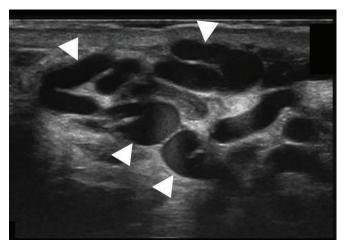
Ultrasound scan showing numerous distended veins (arrowheads) in the inguinal canal.
